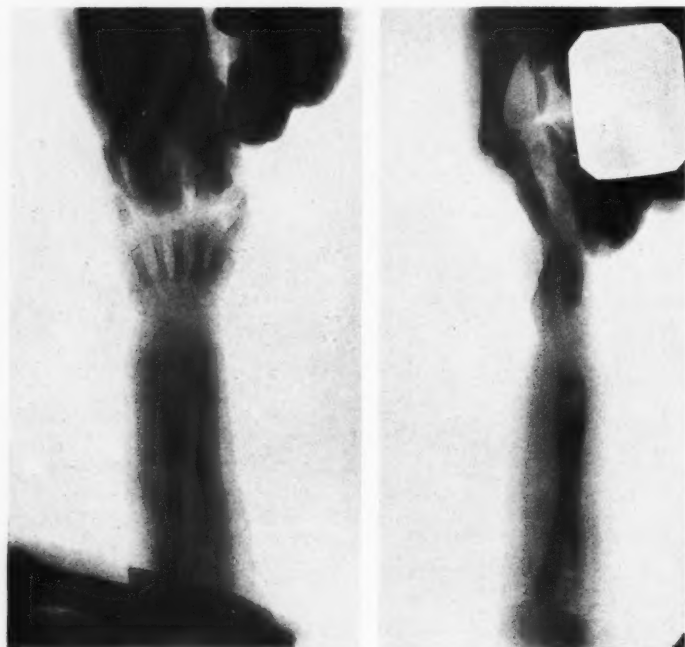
Roentgenogram of an osteomyelitis in a child aged four. The area of bone destruction invades the epiphysis, and the periosteal reaction, with new bone, slopes upward beyond the mid-shaft region.
